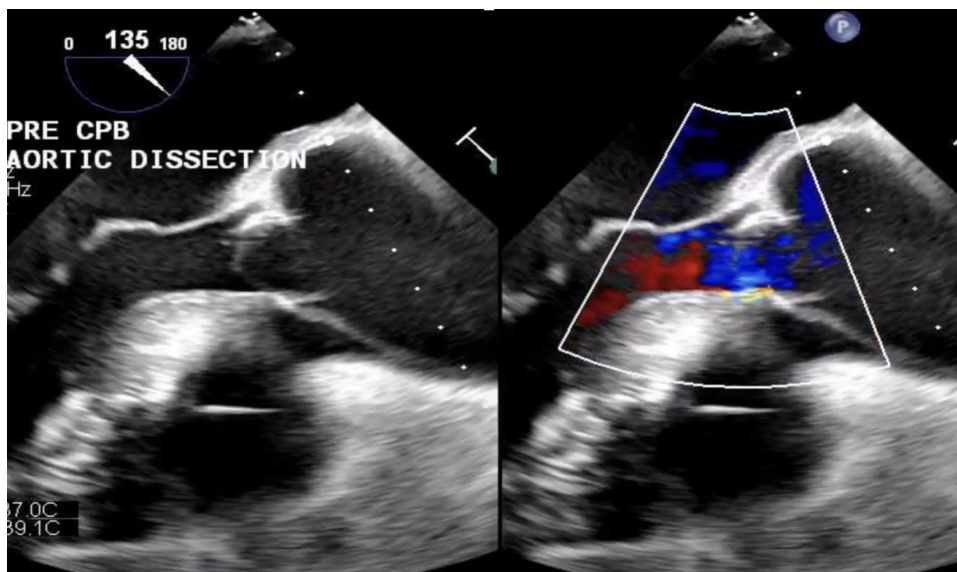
TEE ME Long Axis – Diastole. Dissection flap originates within the aortic root just distal to the aortic valve. Color doppler demonstrates retrograde blood flow thru the aortic valve during diastole consistent with regurgitation. Dissection flap causes collapse of the true lumen.
